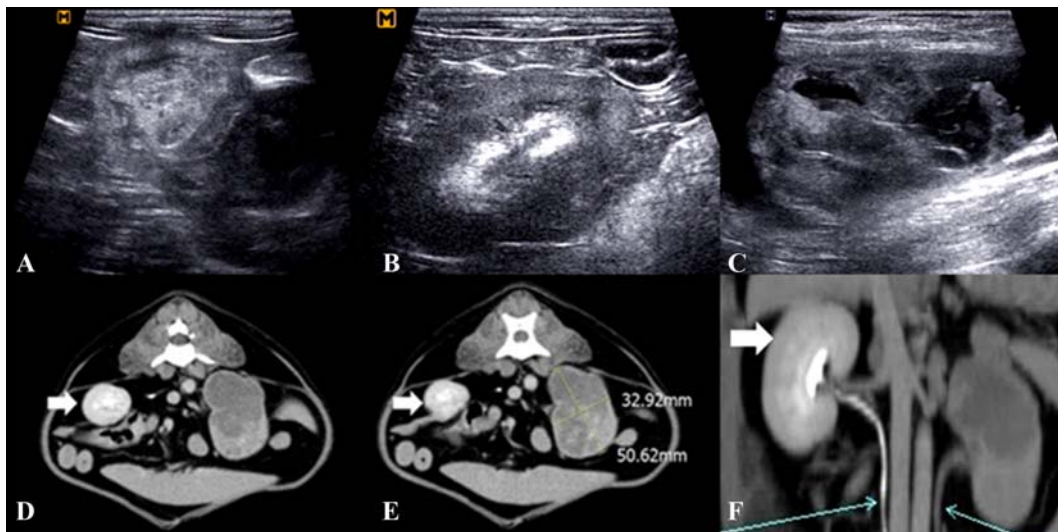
Ultrasonographic and computed tomography (CT) findings. (A) The left kidney showed heterogeneous echogenicity and loss of normal structure, measuring 4.8×2.7 cm. (B) The right kidney showed an irregular margin, medullary rim sign, and indistinct corticomedullary junction. (C) A large blood clot was noticed within the urinary bladder. (D and E) Transverse images at the renal phase, enlarged left kidney without contrast enhancement, hypoattenuation at inside, multiple small mineralized lesions. The size of the left kidney measured 32.92×50.62 mm. The contrast enhancement was noted only within the right kidney (arrows). (F) The CT angiography at the excretory phase noted the contrast enhancement within the right kidney (thick arrow) and ureter (thin arrows).
